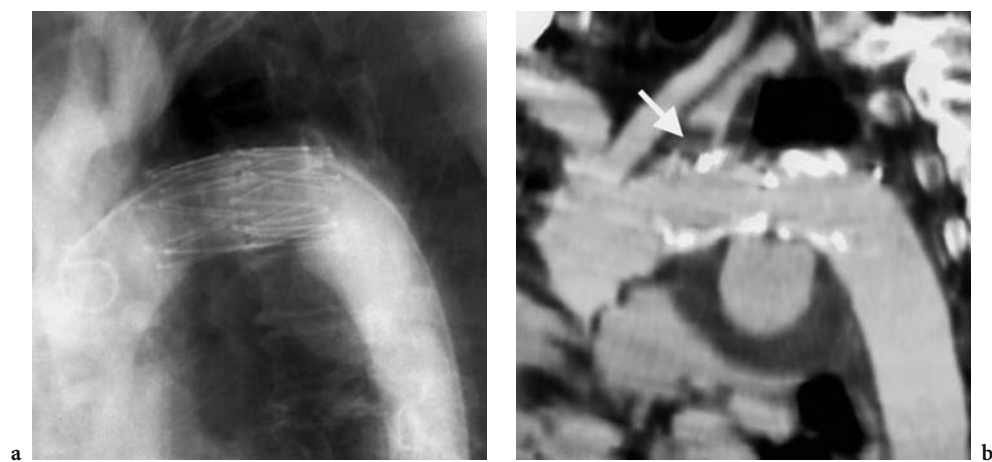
a Aortogram status after deployment of a stent-graft (Dacron covered modified Z stent) over a pseudoaneurysm of at the aortic isthmus. The pseudoaneurysm appears to be completely thrombosed. b CPR CTA obtained 4 h after stent-graft deployment demonstrates that the pseudoaneurysm is still patent. Additionally, the stent graft covers the origin of the left subclavian artery, and a thrombus (arrow) has formed in the proximal left subclavian artery. The patient underwent transection of the left subclavian artery approximately 5 cm from its origin through a limited incision in the neck. The distal left subclavian artery was transplanted onto the left common carotid artery
